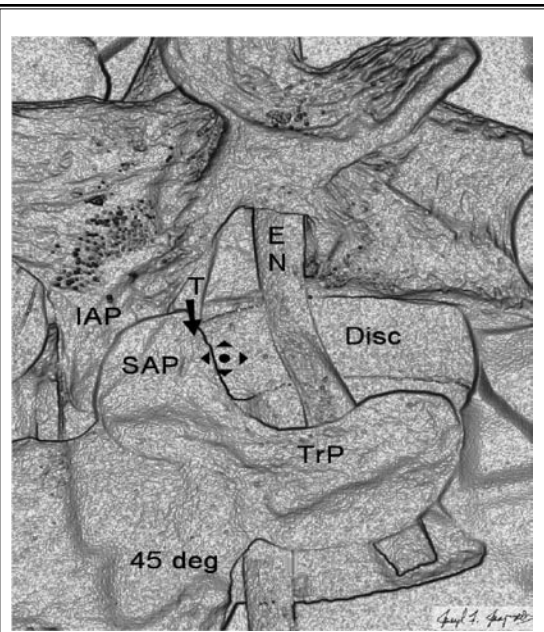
The spine model in a 45-degree oblique demonstrates the landmarks commonly seen during discography and used for retrodiscal injection. Superior articular process (SAP); transverse process (TrP), disc, and inferior articular process (IAP) are in relationship to the exiting nerve (EN) and transiting nerve (T). The cross hairs mark the target for the needle placement down the x-ray beam.
